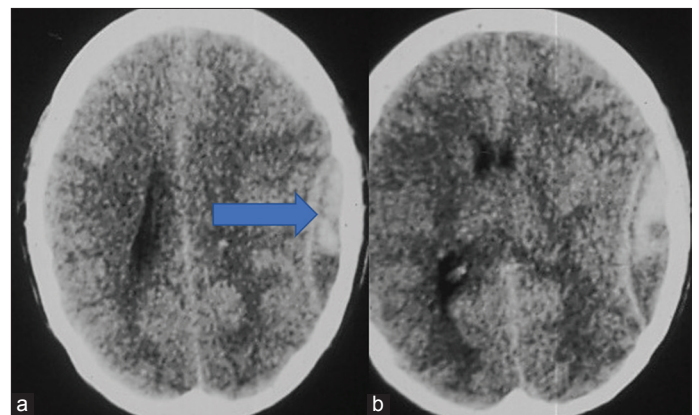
(a and b) Axial views of non-contrast computed tomography brain showing left parietal extradural hematoma (arrow)
